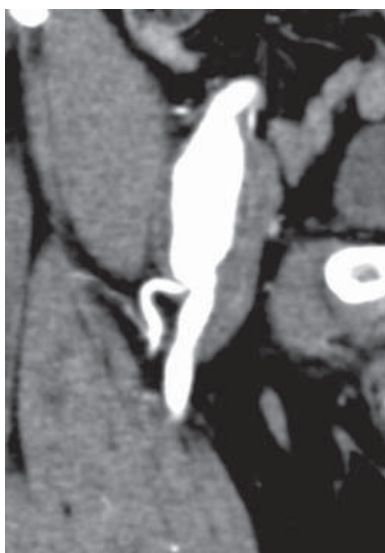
Computed tomography of the aneurysm.
